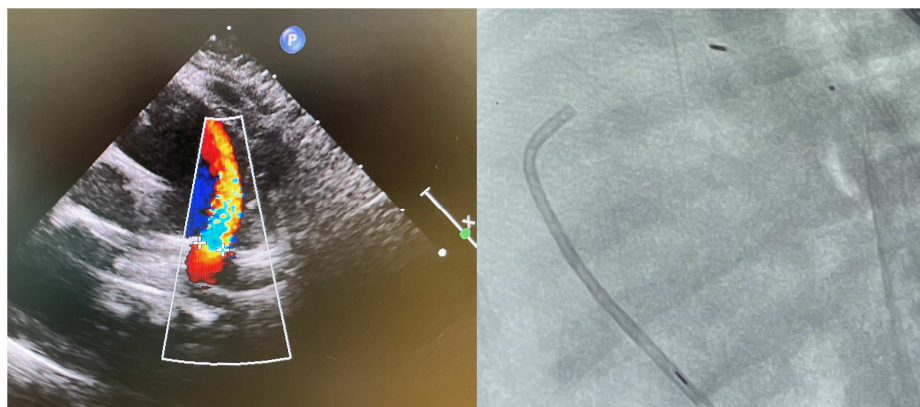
Shows the echocardiography with color-Doppler tubular of a tubular, fetal-like type left-right shunting arterial duct and the fluoroscopy frame after ductal closure by a MVP-5Q (Medtronic® plug system) in a lateral projection.
